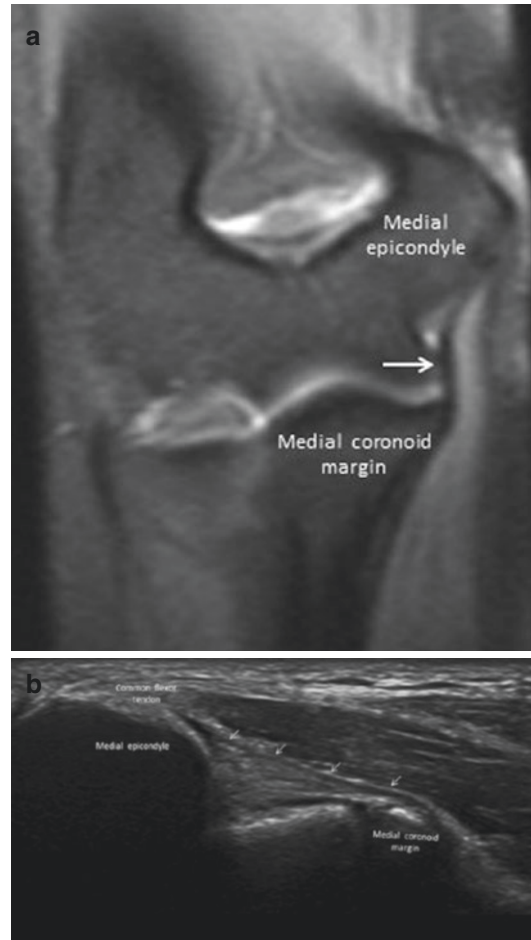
Anterior band of the medial collateral ligament. The anterior band (arrow) arises from the inferior aspect of the medial epicondyle and inserts distally at the sublime tubercle of the ulna (a: MRI image). It is generally examined in the same position as the common flexor tendon and appears hypoechoic (arrows) (b)
